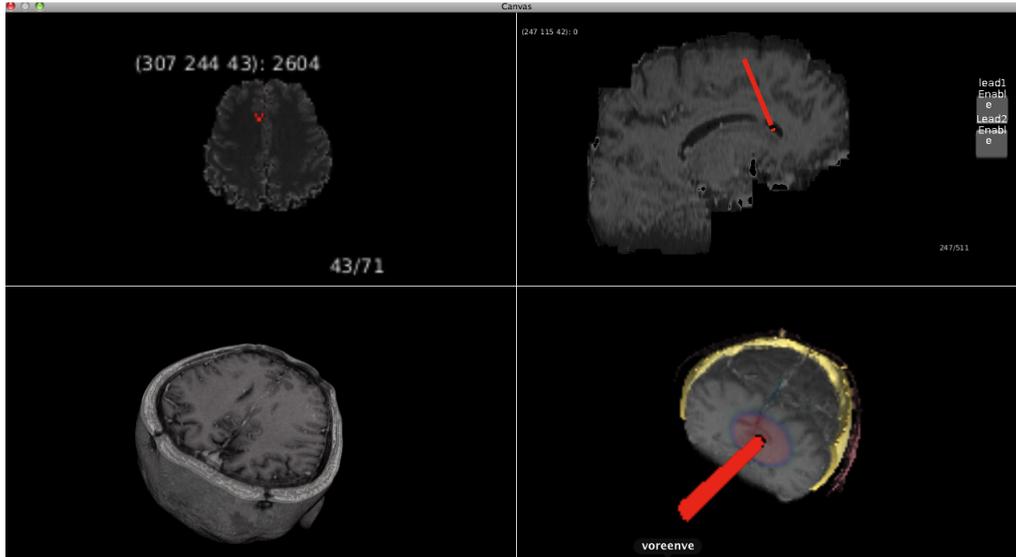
The top left view is axial view. The top right view is sagittal view. The bottom left view is MRI. The bottom right is reconstructed volume with a lead
